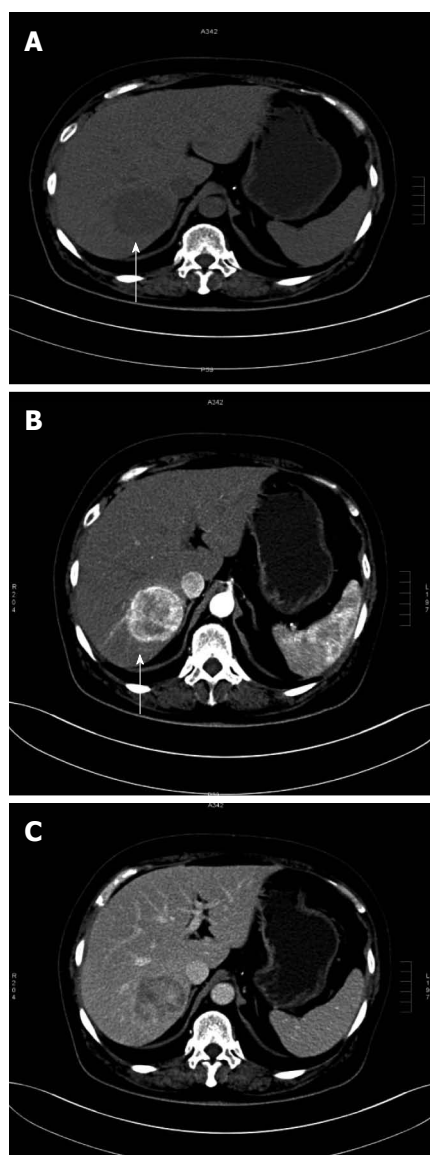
Computed tomography plain scanning: oval mass in posterior segment of the right hepatic lobe, slightly low density, clear boundary, and uniform density (A); venous phase: the enhancement of foci weakening (B); arterial phase: obvious and uniform enhancement of foci (C).
